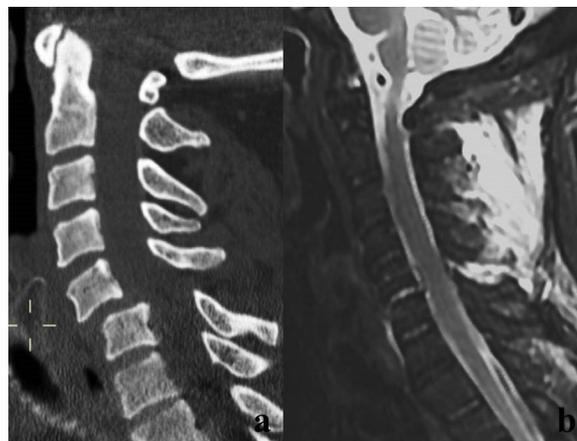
(a and b) Skier after a fall. CT midline reformatted scan showing hyperflexion trauma with anterior C5 dislocation. The patient being neurologically normal, did undergo a closed reduction. For the appearance of paresthesia a RM was performed. Sa sagittal midline STIR MR scan depicting a C5-C6 herniation associated to a focal epidural hematoma. Fact dislocation is an injury often complicated by traumatic disc herniations. A preoperative MR should always be performed before any treatment.
